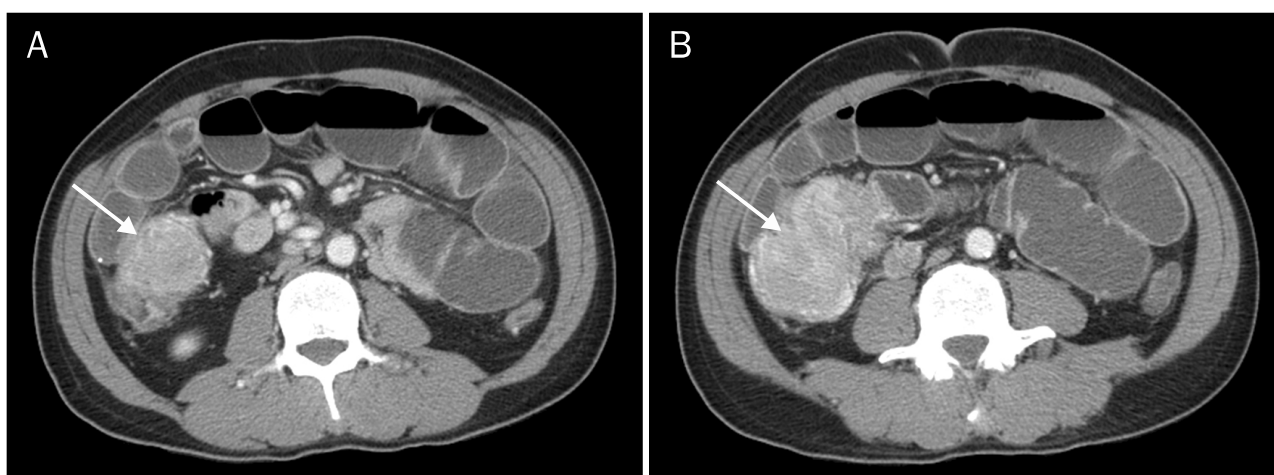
The CT scan reveals an intraluminal annular enhancing mass (arrows) in the terminal ileum to proximal colon area with small bowel dilatation.
